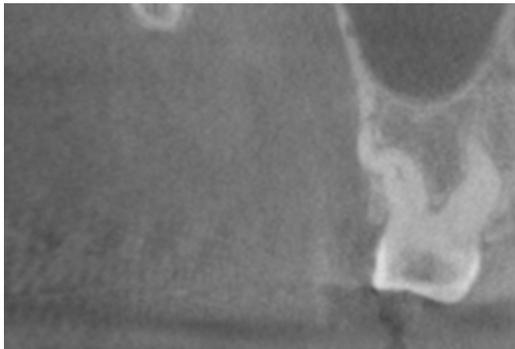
CB-CT image showing the S-shaped anatomy of DB root.
